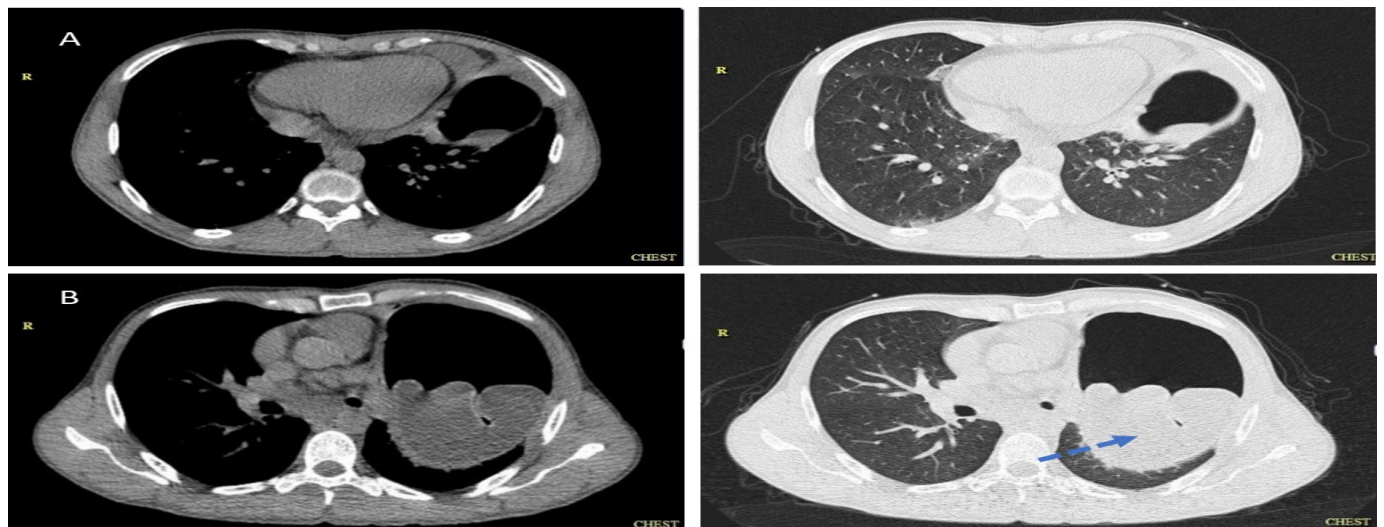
Imaging findings associated with the patient's condition. (A) High-resolution CT scan demonstrating lower lung collapse and detachment of the inner layer adjacent to a pericardial effusion (180 x 110 mm) with a visible air-fluid level. (B) The "water lily" sign is indicative of a ruptured hydatid cyst in the left lung
